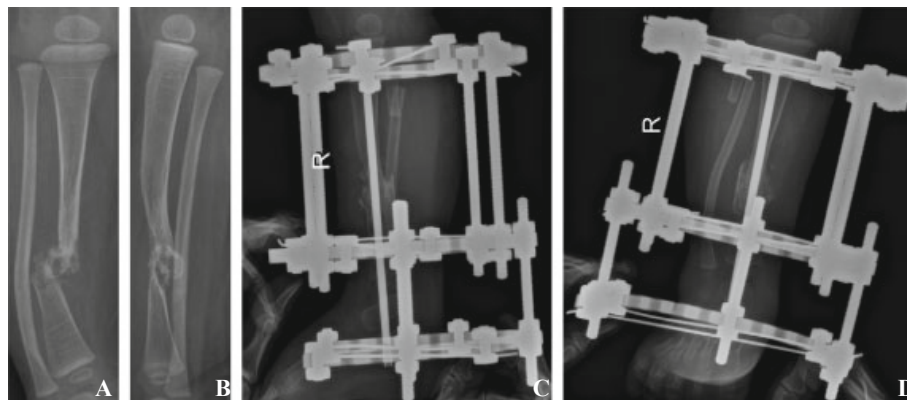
X-ray of the site at 1 week pre-operation and post-operation. A: Anteroposterior of the tibia before surgery; B: Lateral of the tibia before surgery; C: Lateral radiography at one week after combined surgery; D: Anteroposterior radiograph of the same patient taken at one week after combined surgery.
